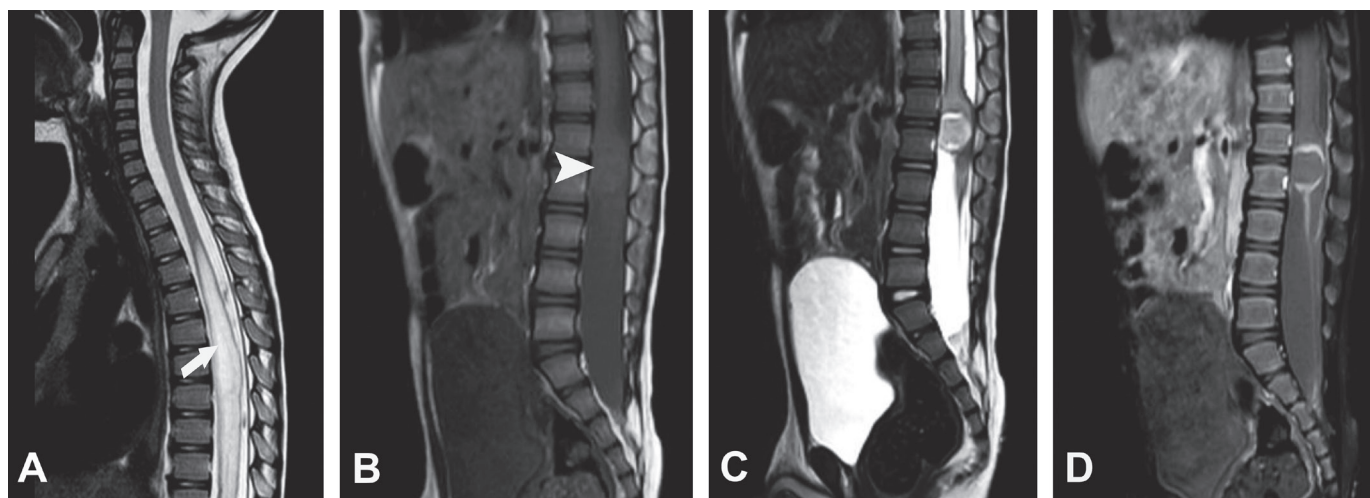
In the preoperative (A) thoracic MRI, a syringohydromyelia (arrow), extending from T4 to L1 vertebrae, was observed. Lumbar MRI (B) T1-weighted sagittal image showed hypointense expansion (arrowhead) at the L1-2 vertebrae level. (C) T2-weighted image showed a lesion that had hyperintense capsular formation with isointense content and that excessively compressed the conus medullaris. (D) T1-gadolinium-enhanced image demonstrated that dense cystic mass had circumferential contrast enhancement. Besides, some cauda equina fibers had contrast enhancement.
